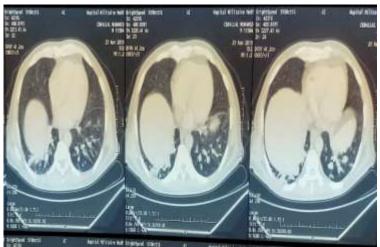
Chest CT scan: diffuse pulmonary micronodules related to miliary tuberculosis.
